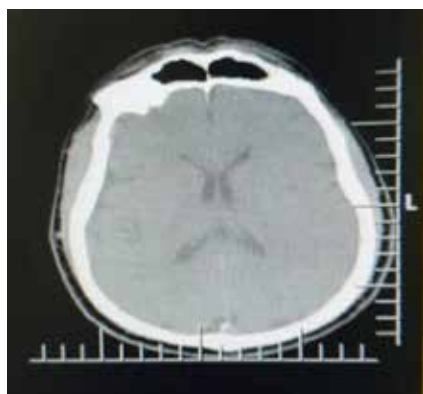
Normal brain CT scan.
